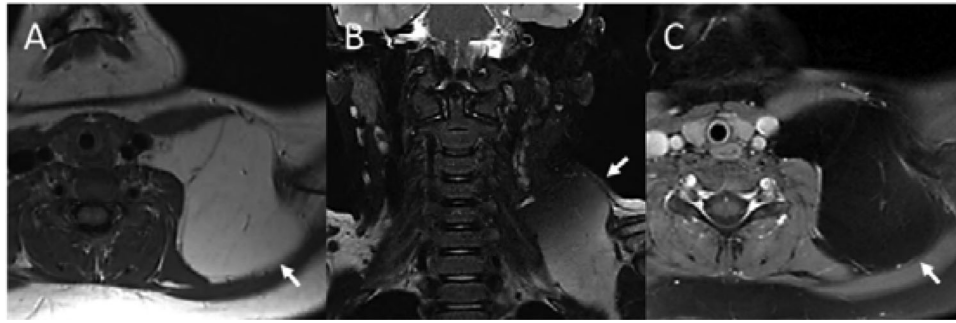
Axial T1-weighted (A), coronal fat-suppressed T2-weighted (B), and axial fat-suppressed postcontrast T1-weighted (B) MR images of a child with a large lipoma. The axial image (A) shows a homogenous mass in the left periclavicular region with signal intensity similar to subcutaneous fat. The postcontrast image (C) demonstrates no enhancement after contrast administration. The fat suppressed images (B, C) confirm the diagnosis of lipoma by homogenous suppression of the lesion in comparison with the conventional T1-weighted image (A).
